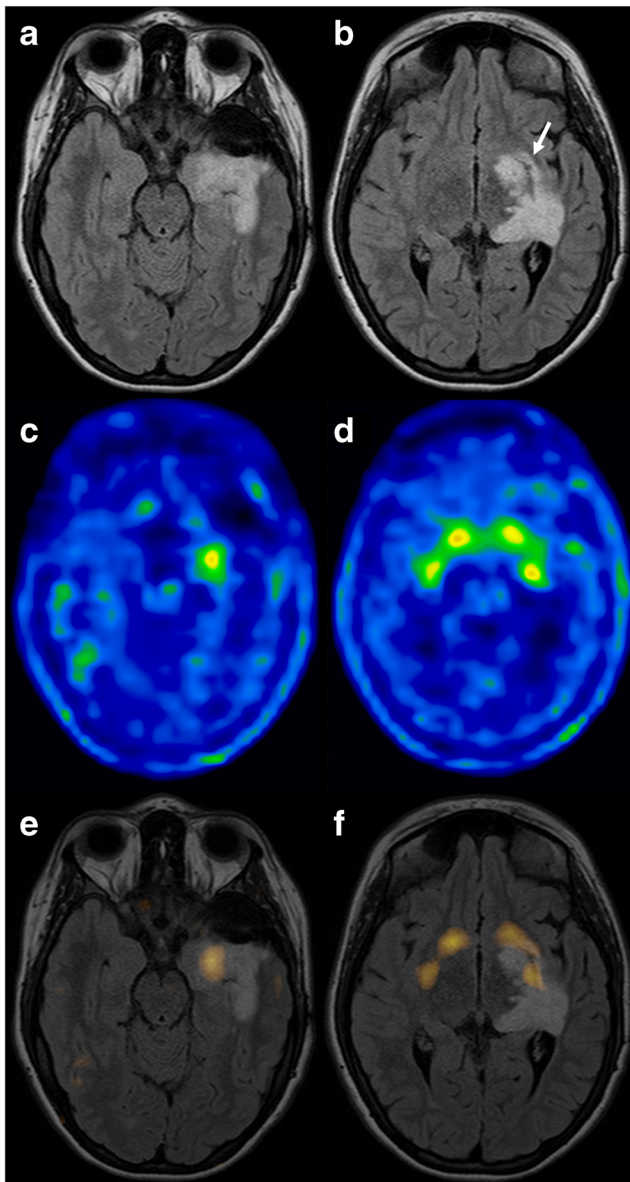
False-negative ^{18}F -DOPA PET/CT and ^{18}F -DOPA PET/MRI images. Ganglioglioma (patient 2). a, b The axial FLAIR images show a lesion of the left temporal lobe involving the ipsilateral ventral striatum (b arrow). c–f PET/CT images (c, d) and fused PET/MRI images (e, f) show only focally increased uptake in the lesion in the left uncus region, and do not show involvement of the ventral striatum
